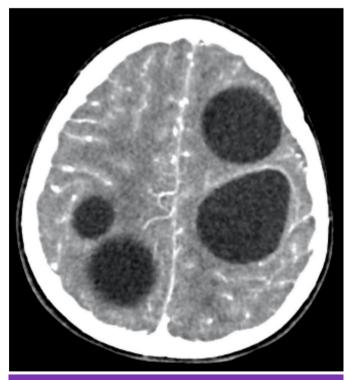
Brain CT showed multiple smoothly circumscribed cystic lesions, the largest of which was 46x49x48 mm in size, without compression effect and edema, without calcification, and located in the supratentorial region CT: Computed tomography
